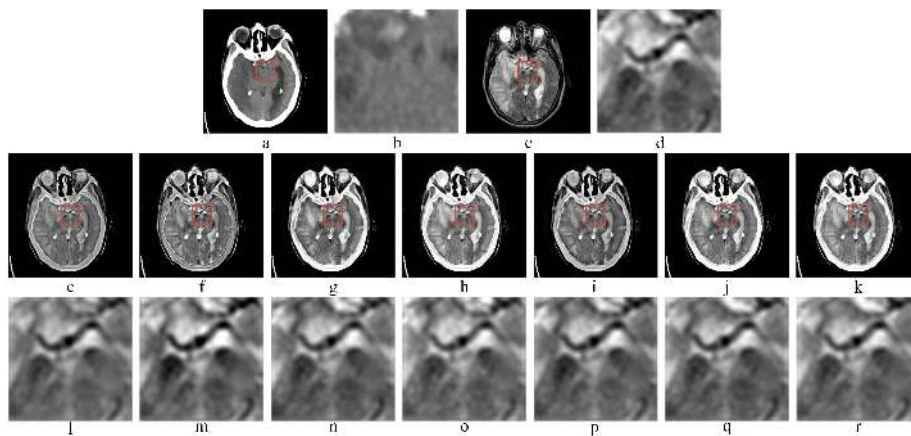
CT-MRI image fusion experiments, (a) and (c) are CT and MRI source images respectively. (b) and (d) are local detailed images of (a) and (c) respectively. (e), (f), (g), (h), (i), (j) and (k) are the fused images of ASR, JCPD, MST, NSST, NSCT, NSCT-PC and proposed methods respectively. (l), (m), (n), (o), (p), (q), and (r), are local detailed information of (e), (f), (g), (h), (i), (j) and (k) respectively.
